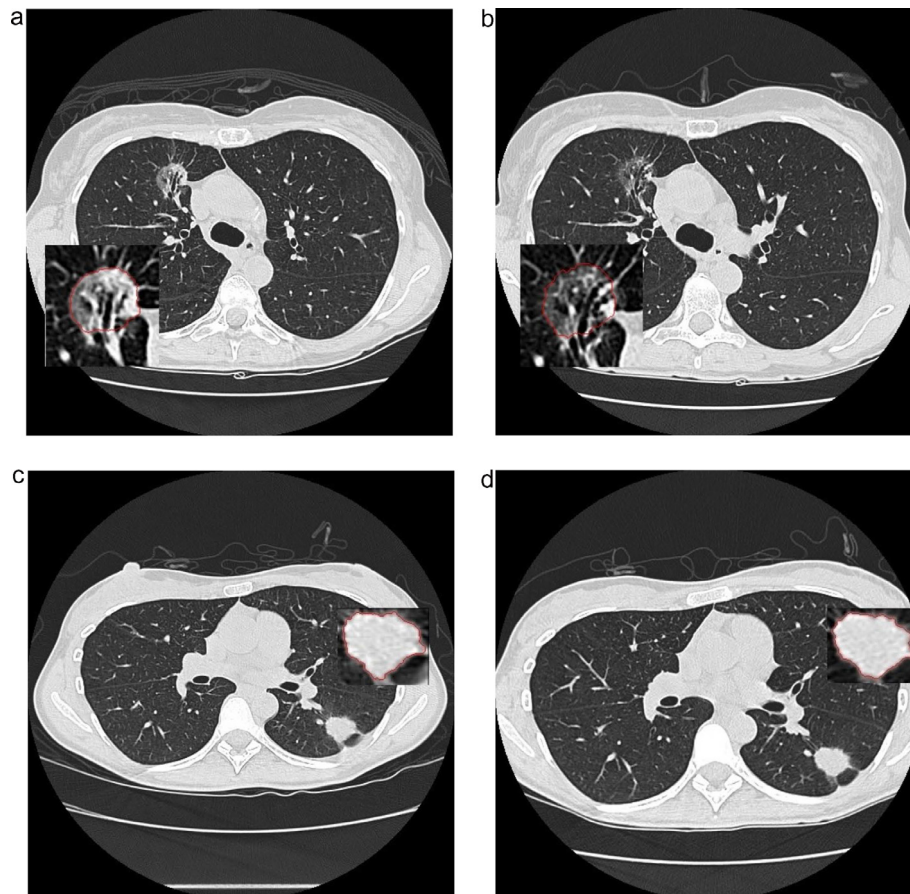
CT images of a patient (1-a and 1-b) with EGFR mutation, and one (1-c and 1-d) with wild-type status. Images were acquired prior (1-a and 1-c) and after (1-b and 1-d) administration of chemotherapy for lung cancer. Some radiomic features related to tumor phenotype and response to therapy extracted from these images, are shown in Table 2 (reproduced from [100] under Creative Common License).
